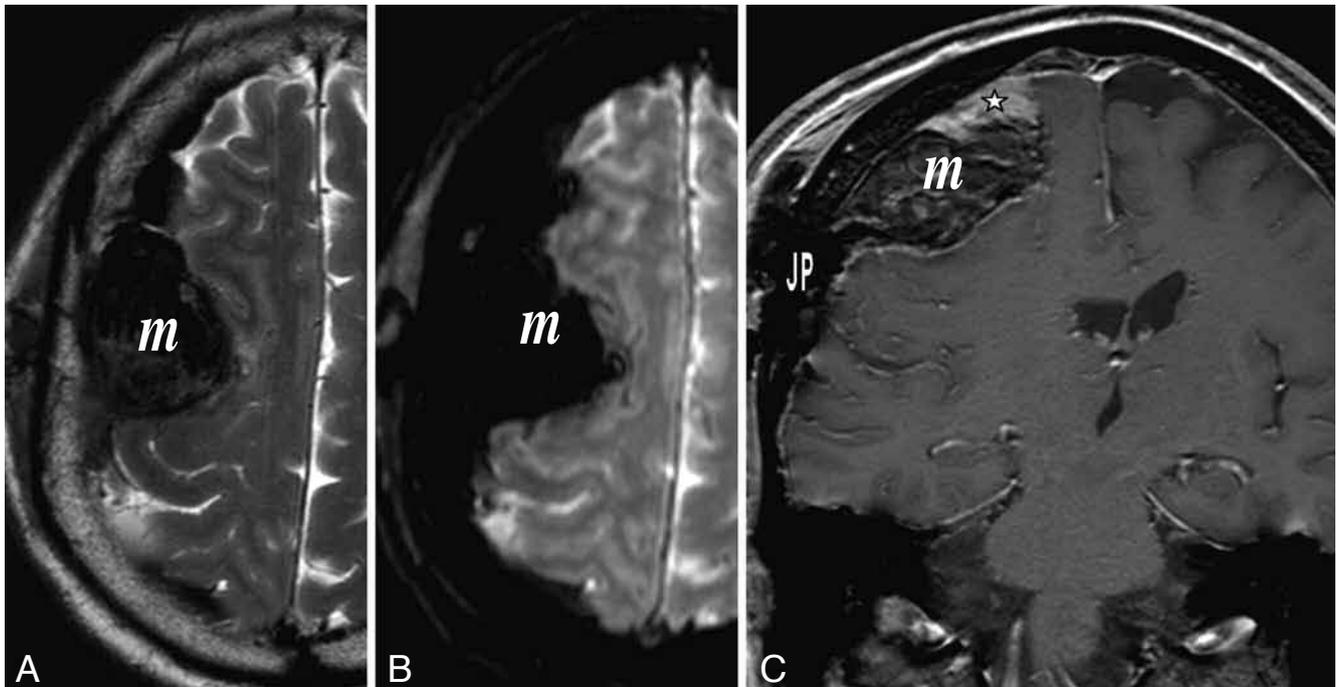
Axial T2 (A) and T2*-weighted (B) and frontal post-contrast T1-weighted images (C) MR views after surgical drainage of the subdural hematoma. Very low hypointense T2 and T2*-weighted signal (together with susceptibility artifacts) confirmed intratumoral hemorrhage (m – meningioma). Heterogeneous enhancement is observed after gadolinium injection, restricted to the upper third of the tumor (C – white star). Subdural JP drain is seen as an artifacted low signal area (C – "JP").
